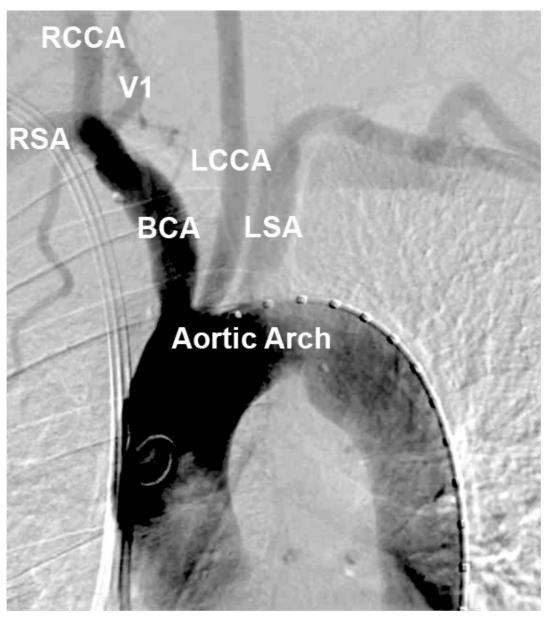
(Left) Computed tomography (CT) angiographic reconstruction of the AA. (Right) Digital subtraction angiography (DSA) of the AA and its large branch vessels.
